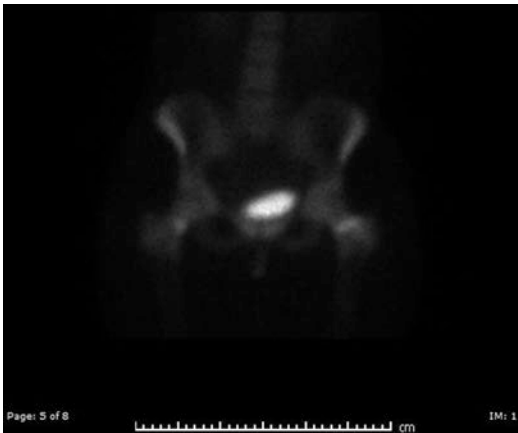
Bone scintigraphy of a patient with bilateral hip pain which identifies bilaterally increased uptake at the femoral neck, greater on the left than the right, consistent with bilateral femoral neck stress fractures
